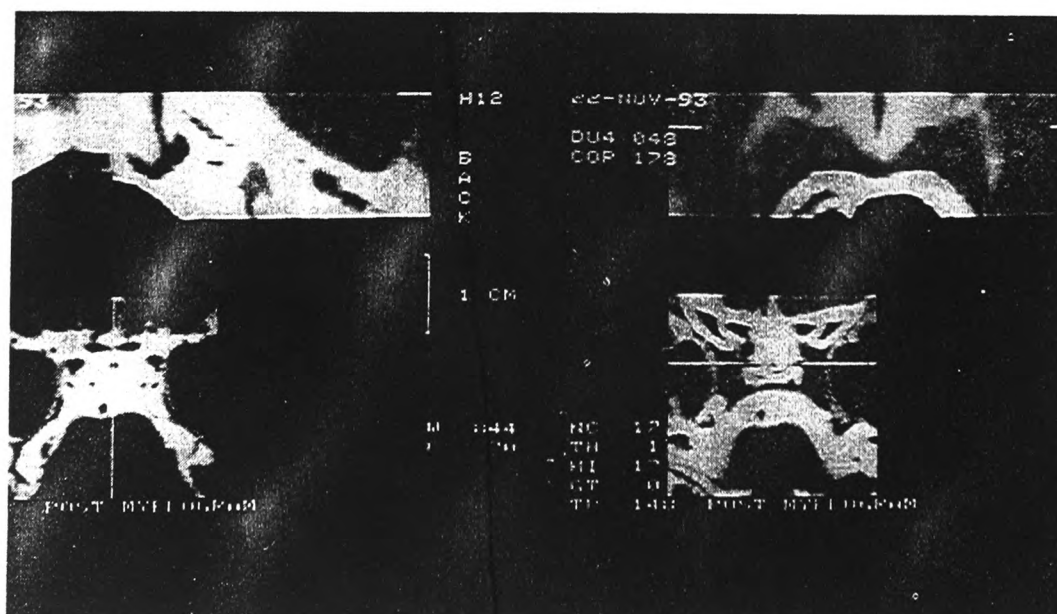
CT after intrathecal contrast examination in a 12-year-old girl with SCD: sagittal reconstruction (left) and coronal reconstruction (right). Both show gross herniation of the suprasellar cisterna.
